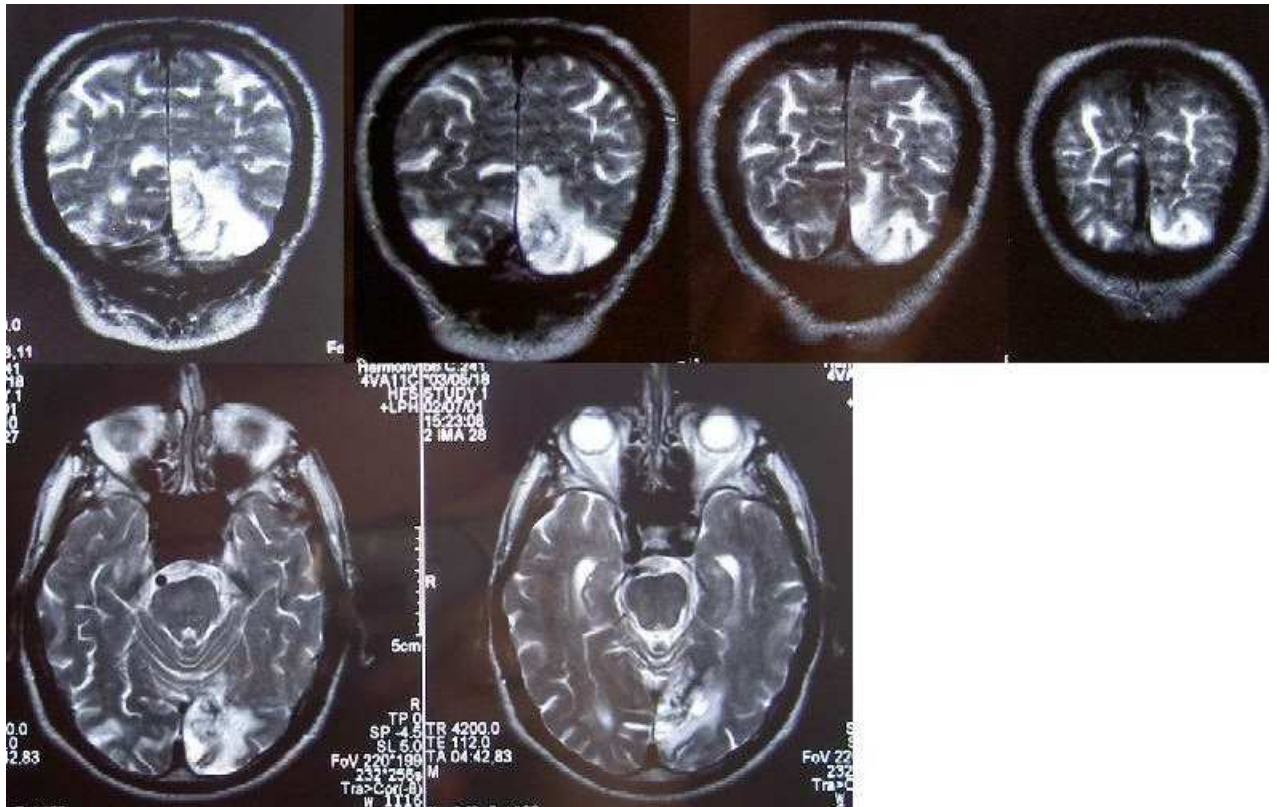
MRI scans of FC. The coronal and axial sections show the left posterior occipital lesion which involves the occipital pole, the lingual gyrus, the occipital fusiform gyrus and the underlying paraventricular white matter in the left hemisphere. A smaller right occipital lesion is also present in the lateral occipital gyrus. The corpus callosum is intact.
